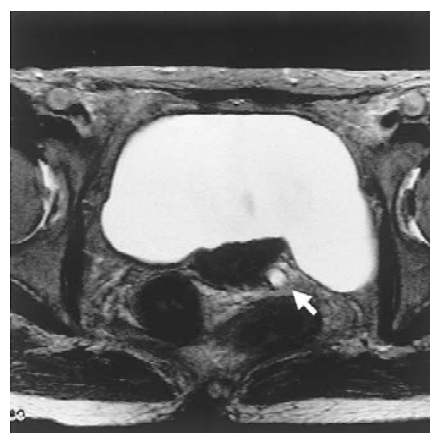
Magnetic resonance imaging (MRI) revealed an irregular thickened bladder wall, which suggested that the lesion had extended to the perivesical tissues and left ureters (arrow).
